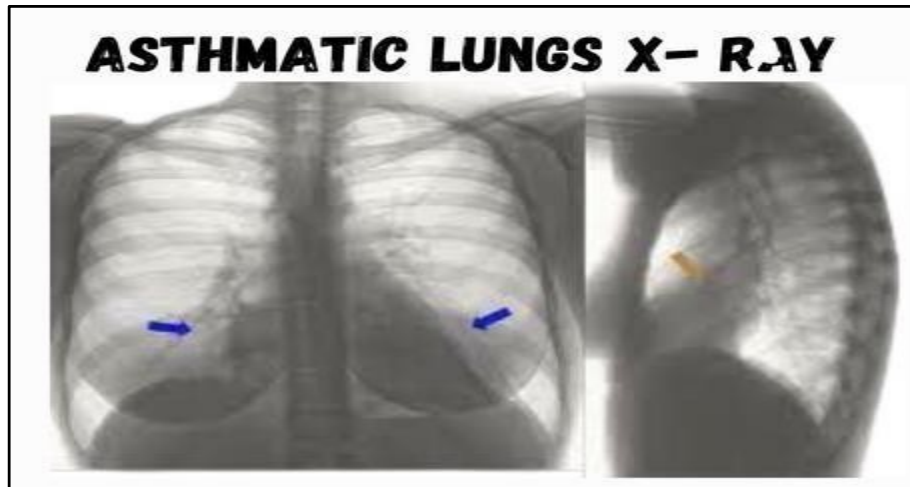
Lung X-ray [8].
